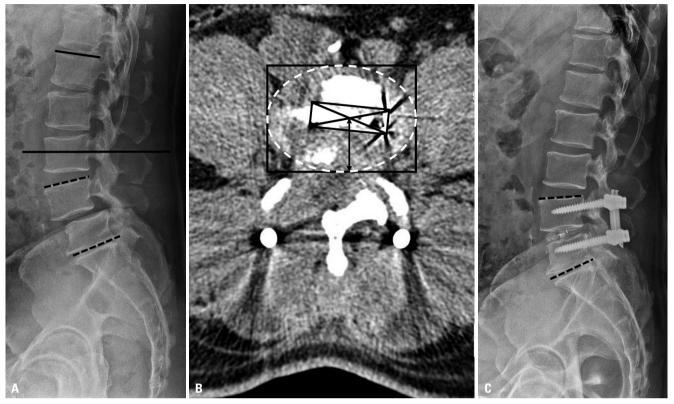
Patient with increased segmental lordosis after surgery even though the cage was not positioned anteriorly. This patient had small preoperative segmental lordosis (black dotted line, 6.2°) and proximal lordosis (black line, 6.7°) (A). Even though the cage was not positioned anteriorly enough (black arrow, 44.4%) in the axial CT image (B), postoperative segmental lordosis increased by 20.5° (black dotted line) on 1-year postoperative X-ray (C).
